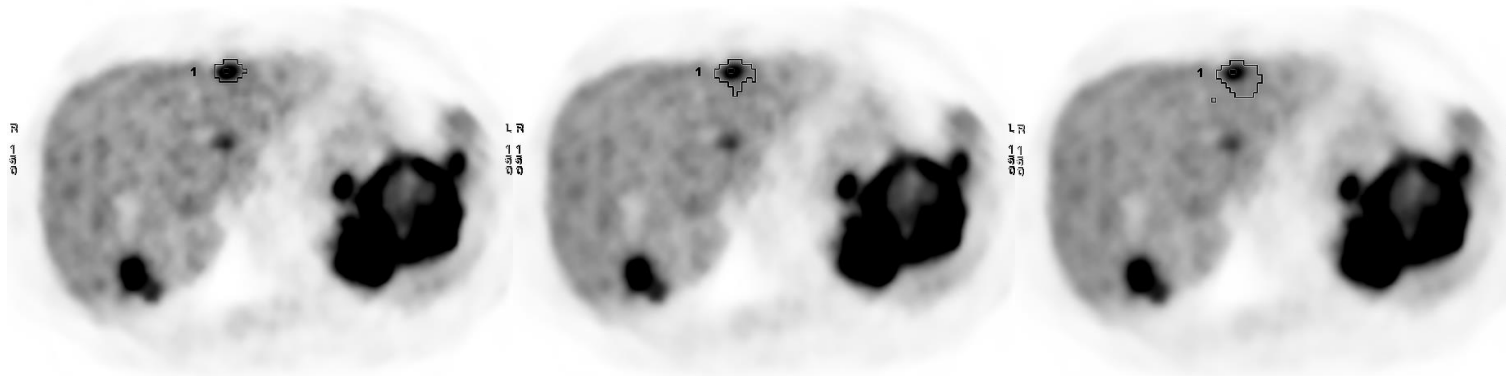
1 1-layer of the PET/CT image series obtained for the patient with neuroendocrinal tumour with marked lesion of pathological uptake. From left side: images obtained with the VP HD+Q. Clear reconstruction technique with Beta in range 350-550, step 100.
